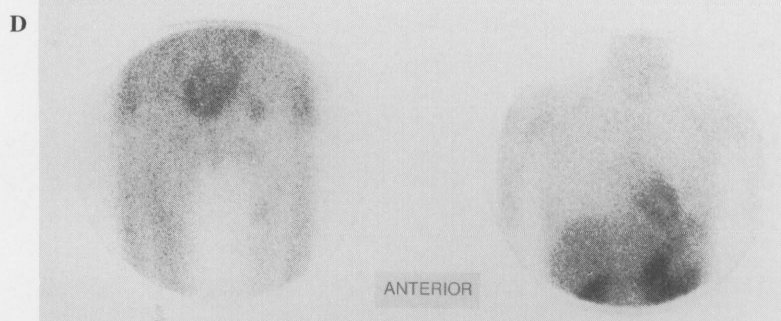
Female, 24 yr, with a local recurrence of synovial sarcoma and lung metastases. CT scan (A) abnormal mass in the left thigh and chest X-ray (B) shows multiple lung metastases. Early scintigram (C) shows 2 abnormal accumulations in the left thigh. Delayed scintigram (D) shows the same accumulations (left) but shows no abnormal uptake in the lung (right). Ga-67 scintigram (E), a week after the Tl-201 examination, shows no uptake in both the tumors and the lung metastases. T/BG ratio of the early and the delayed scintigram is 1.29 and 1.09, respectively.
